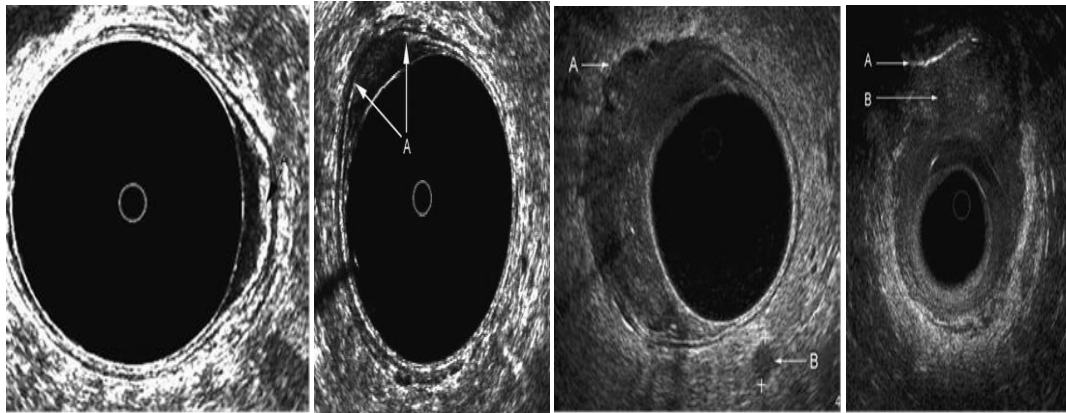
Staging Modalities by Trans Rectal Ultrasound (TRUS)[T1 Tumour,T2Tumour,T3 Tumour,T4 Tumour]
